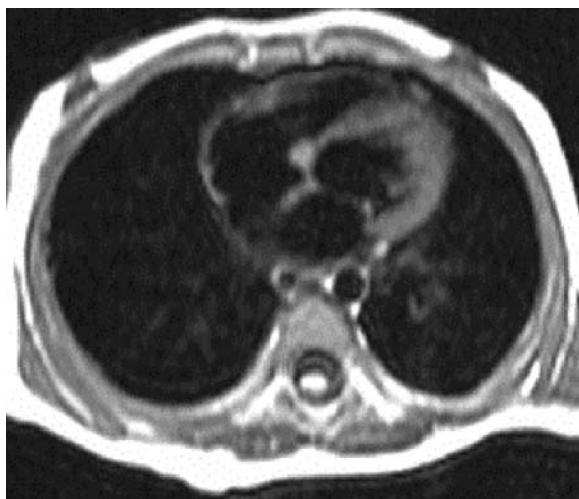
Transversal view. SE, T1-weighted sequence. A small nodule originating from the septal wall is visible in the right ventricle, on the border with tricuspid valve.
